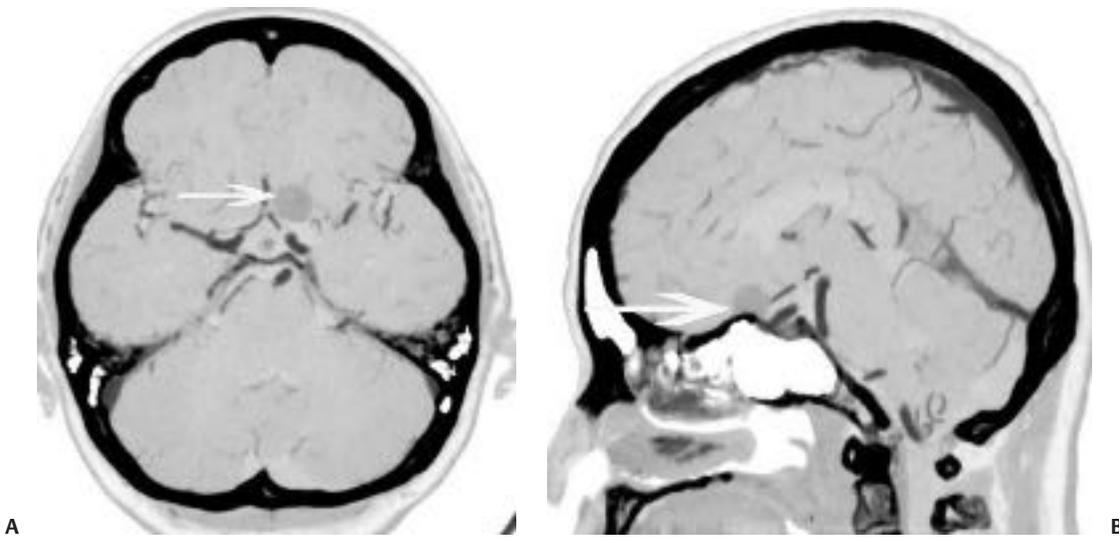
(A) Suprasellar mass lesion adjacent to the left anterior clinoid process that on axial computed tomographic angiography (CTA) could be mistaken for an aneurysm. (B) Reformatted sagittal image demonstrates no true connection with artery. Diagnosis was meningioma.
